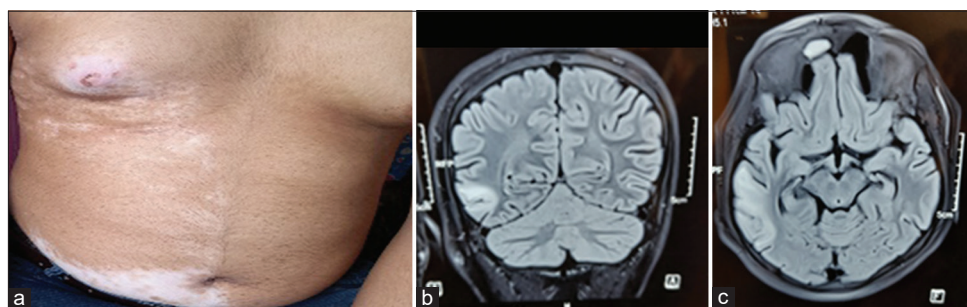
(a) Clinical photograph of 15-year-boy (Case 3) having nevus achromicus in right trunk. (b) Magnetic resonance imaging (MRI) brain of Case 3 showing focal cortical dysplasia of the right frontal cortex. (c) MRI brain of Case 3 showing right temporal focal cortical dysplasia.
